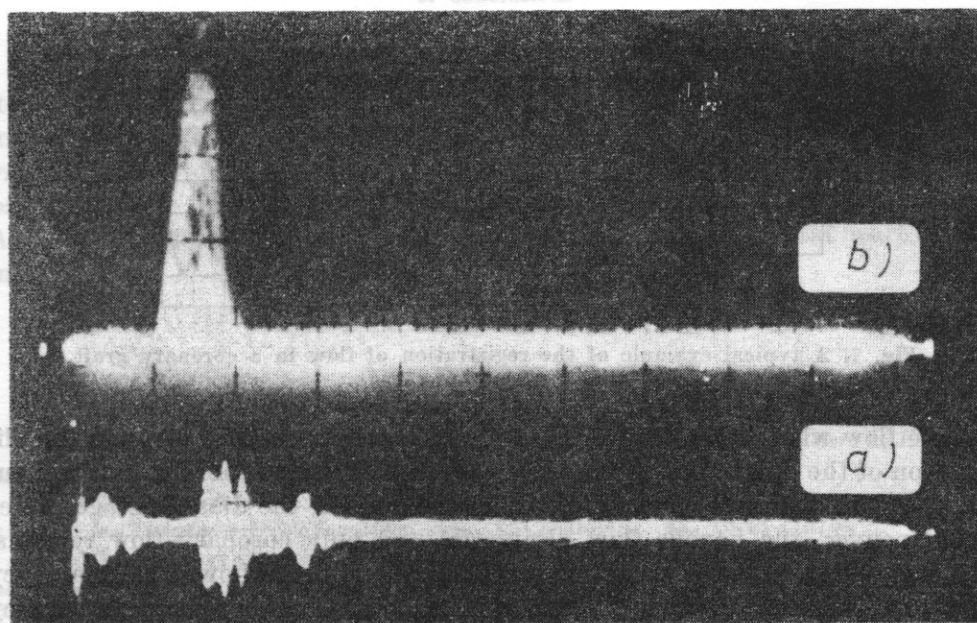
Ultrasonic echoes: a) at the input of the SEC system; b) flow "profile" in the carotid artery. Stationary echo cancellation > 60 dB
